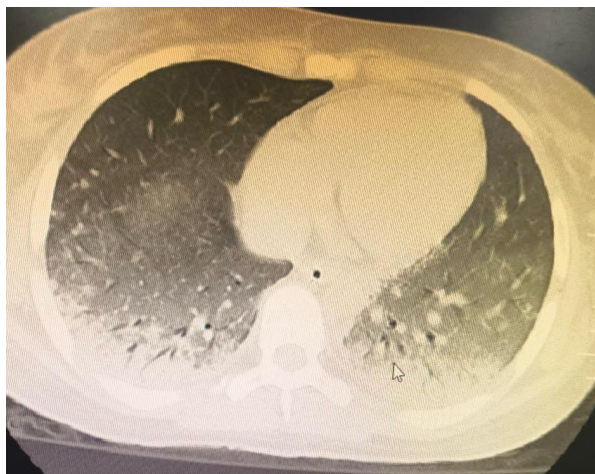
HRCT thorax showing bilateral ground-glass opacities
